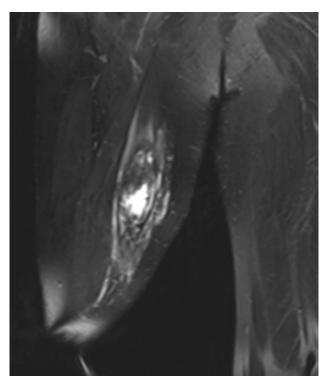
T2 Coronal FS of initial MRI prior to biopsy and procedure demonstrates the long, enhancing mass $(4.5 \times 4.0 \times 10.1 \text{ cm})$
